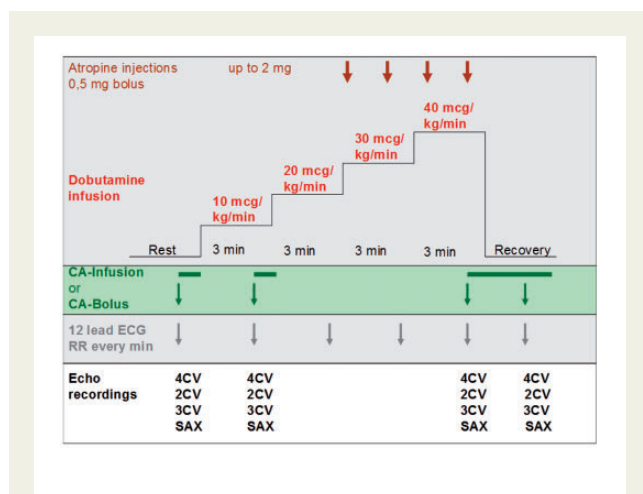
Protocol for dobutamine stress/assessment of ischaemia and using contrast agent (CA) infusion or injections. In this example, the dobutamine infusion had to be increased up to 40 $\mu\text{g}/\text{kg}/\text{min}$ and atropine was injected to reach target heart rate. To minimize the time of the examination, atropine can be started already at the 30 $\mu\text{g}/\text{kg}/\text{min}$ stage when the heart rate has not increased by at least 20% from baseline. Cessation of exercise according to the EAE consensus for stress echocardiography.²¹⁷ For abbreviations, see Figure 10. Additional recordings may also be acquired at intermediate stress (70% of target heart rate).
